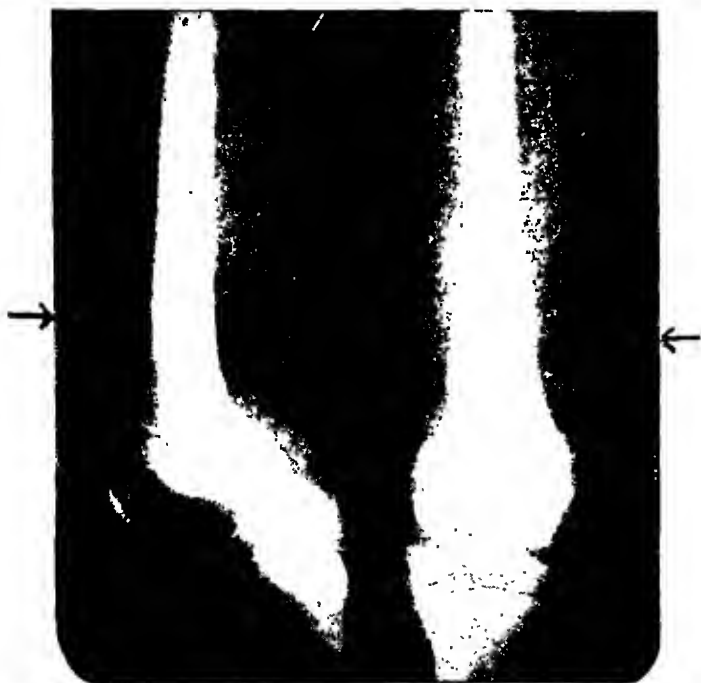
Case 4, J. T.: Roentgenogram of the femur made 27 days after admission to Children's Memorial Hospital.
